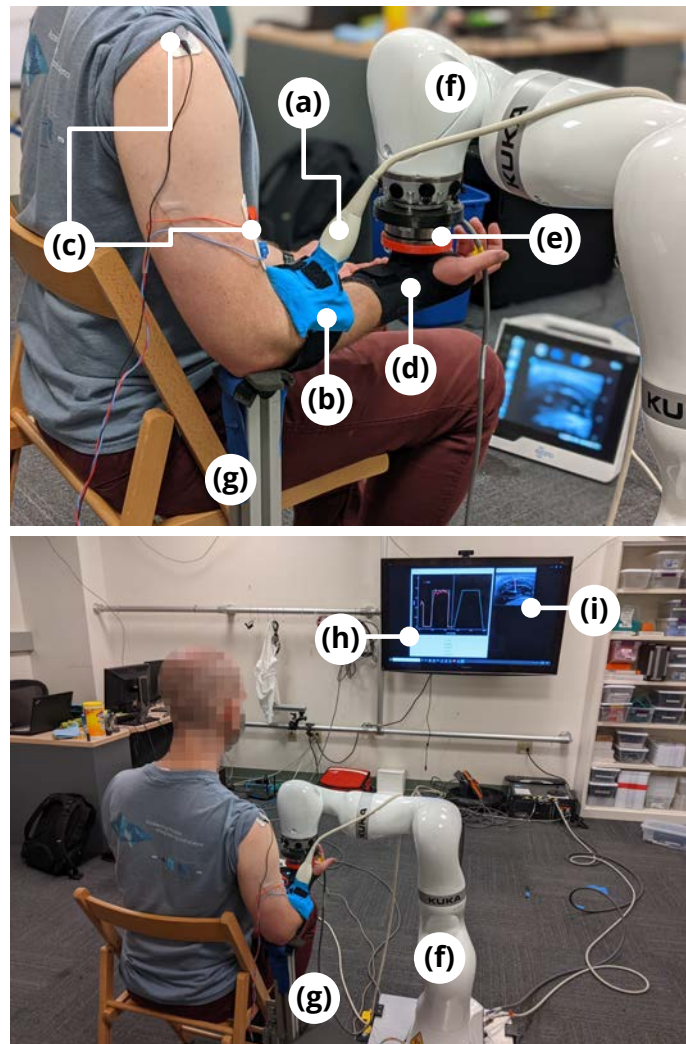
Experimental setup for the collection of time series force, ultrasound, and surface electromyography (sEMG) data during constrained isometric elbow flexion. Setup includes ultrasound probe (a) attached securely to user’s forearm with cuff (b); sEMG electrodes (c); wrist brace (d) through which subject transmits force to attached to force-torque sensor (e), in turn held stable by KUKA robot (f); elbow stabilizing jig (g); goal and sensor trajectory display (h) for real time visual feedback for subject self-assessment; and real-time ultrasound thickness tracking data (i) for continuous experimenter system status monitoring. This system allows subjects to precisely follow a specified force trajectory to enable study of force–deformation correlation under varied trajectory types (section 4.3) and to perform trajectory tracking tasks using experimental deformation- and activation-based signals (chapter 5). ©2021 IEEE.
